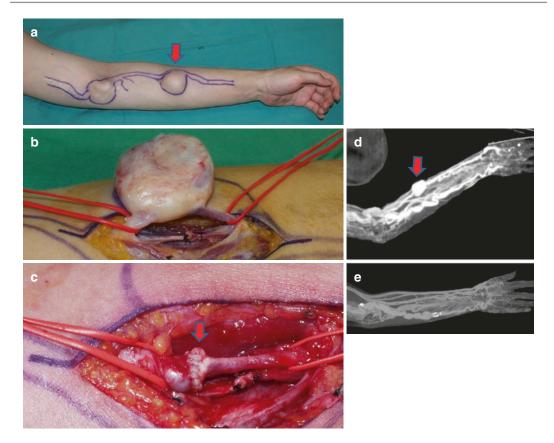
CC: pulsating mass on forearm. Dx: Arteriovenous malformation. (a) preop picture. (b and c) op finding: AVM resection and end to end anastomosis. (d) preop CTA. (e) postop CTA
